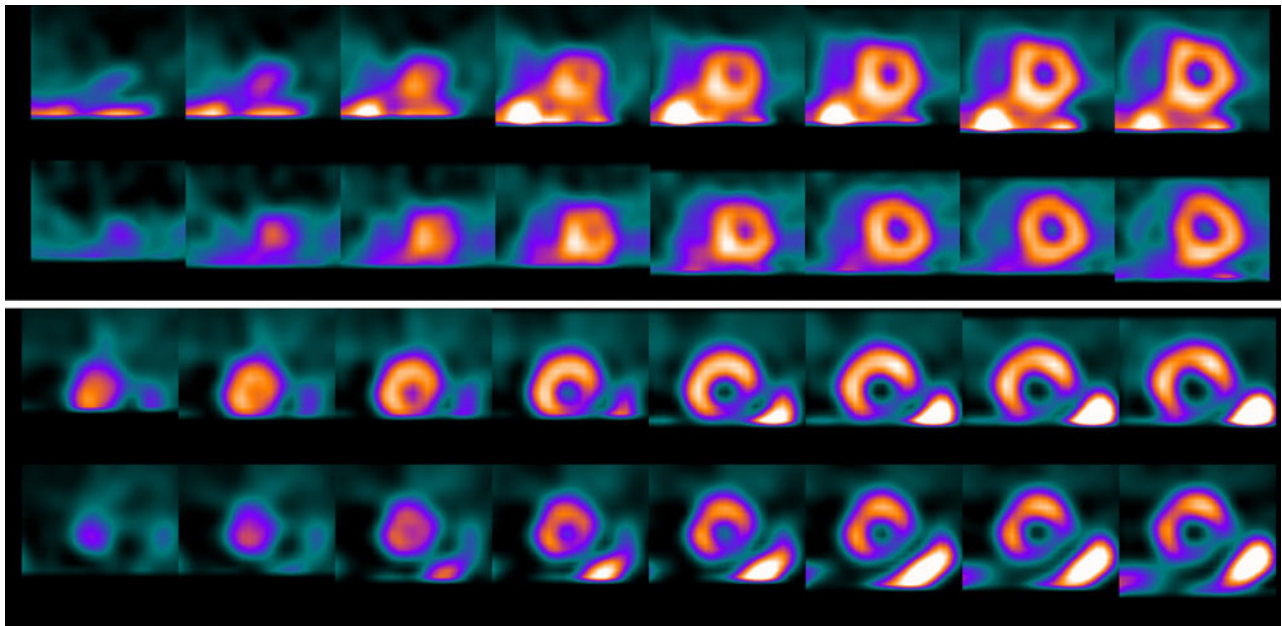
Non-cardiac uptake and render cardiac SPECT study non-diagnostic. The *top image* is an example of cardiac study that has excess liver uptake that spills over into the inferior wall of the myocardium. The lower study is a "ramp-filter artifact" that is caused by the inconsistent views of the bowel activity, creating a drop in counts in the surrounding regions.
